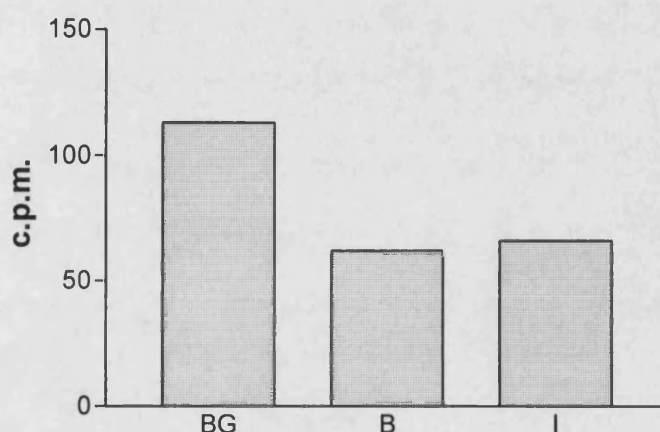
Crosstide-phosphorylating Activity in Rac-CT Immunoprecipitates from Basal and Insulin-stimulated 3T3-L1 Adipocytes.
